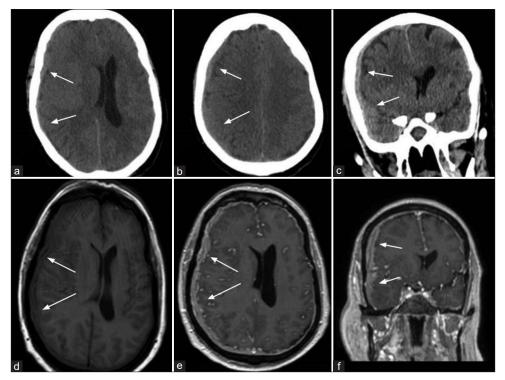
Head computed tomography (a and b) without contrast axial images and (c) coronal image show the slight hyperdense pan-hemispheric subdural collection on the right side (white arrows), causing an 8-mm shift of midline structures. Brain magnetic resonance imaging (MRI) (d) axial T1 image without gadolinium shows a slight hypointense subdural collection (white arrows); (e) brain MRI axial T1 image and (f) coronal T1 image with gadolinium show substantial enhancement of the subdural collection (white arrows) and the shift of midline structures.
